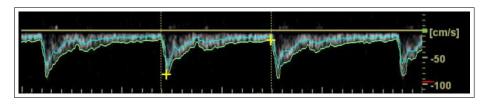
Spectral Doppler trace.
